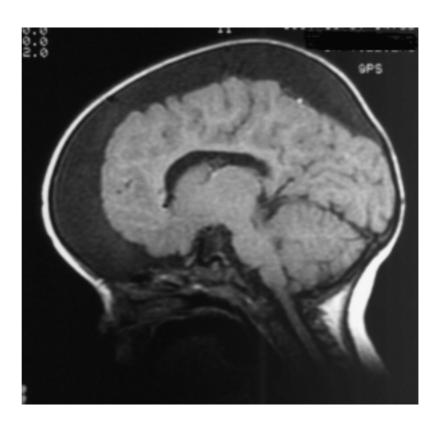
Chronic subdural haematoma. MRI scan showing large chronic subdural haematoma surrounding the cerebral cortex.
